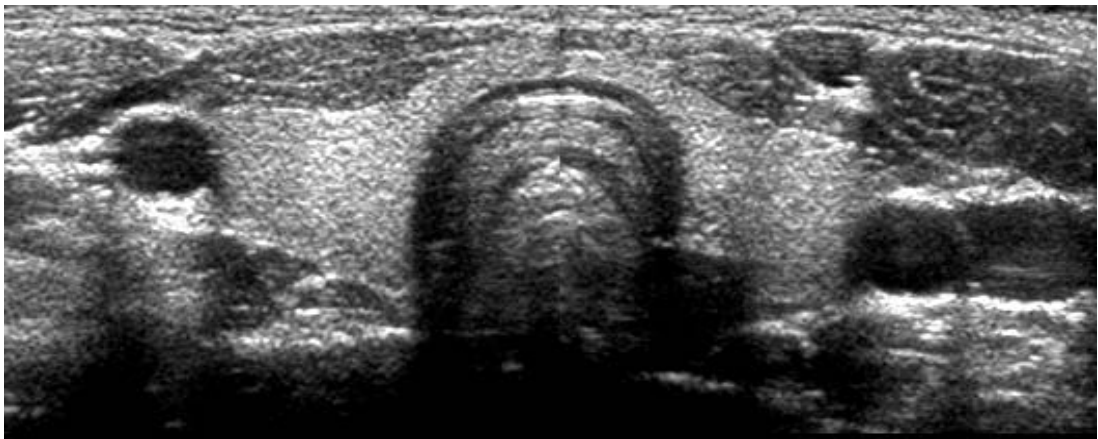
Normal thyroid gland by ultrasound
